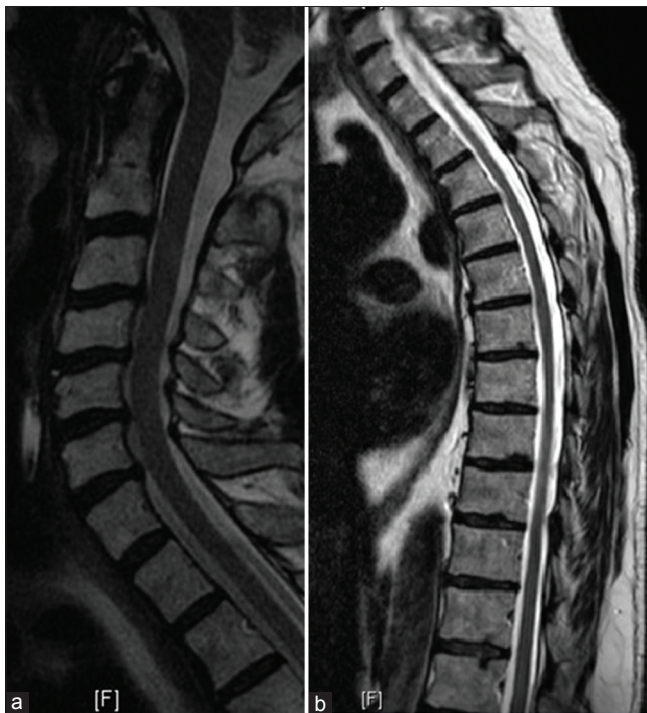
Preoperative sagittal T2-weighted MRI of cervical (a) and thoracic spine (b) demonstrating no lesions or significant stenosis.
